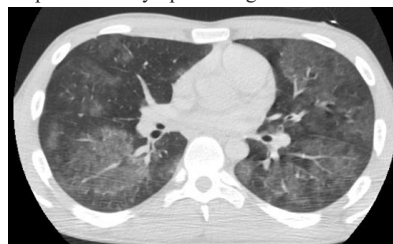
Computed tomography imaging of the thorax showing diffuse ground glass opacities in bilateral lungs
